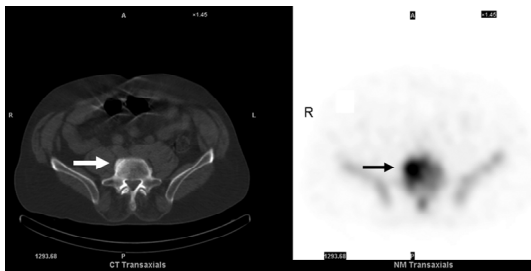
Fused SPECT-CT (axial images) of lower lumbar spine demonstrating osteophytes in L5 vertebra. (The required CT scan is a noncontrast, nondiagnostic, localizing CT with a tube current of 2Ma).
